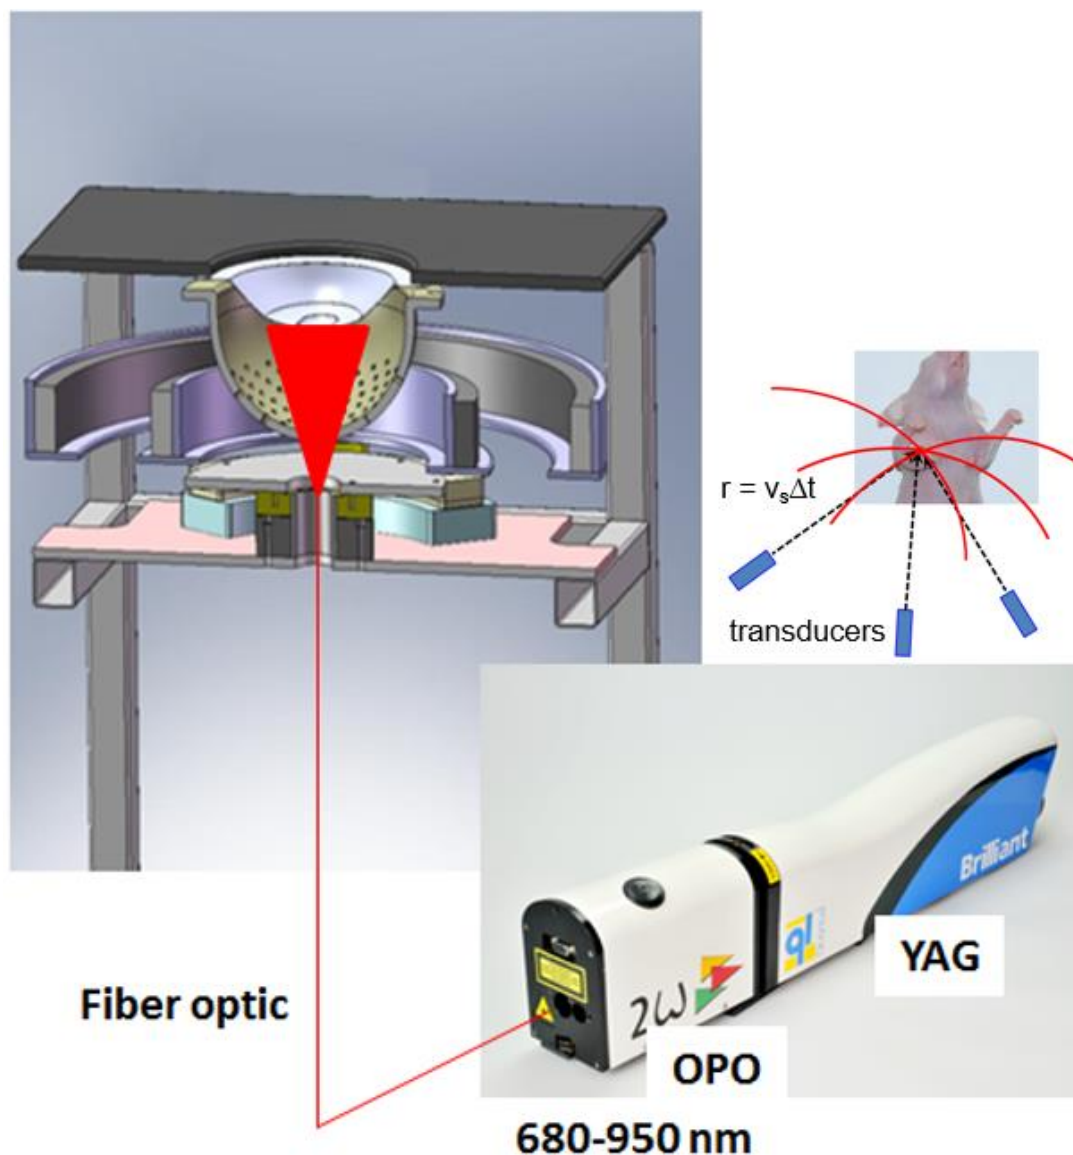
Photoacoustic principles. Pulsed laser energy is absorbed instantaneously into the tissue, causing the tissue to expand due to heating. The expanding tissues push against the surrounding tissue forming an acoustic (or ultrasonic) wave which propagates at nearly constant velocity (v_s). By sampling the waves at various positions, the relative time (Δt) of the signals can be utilized to determine the location and absorption of the molecule (r).
